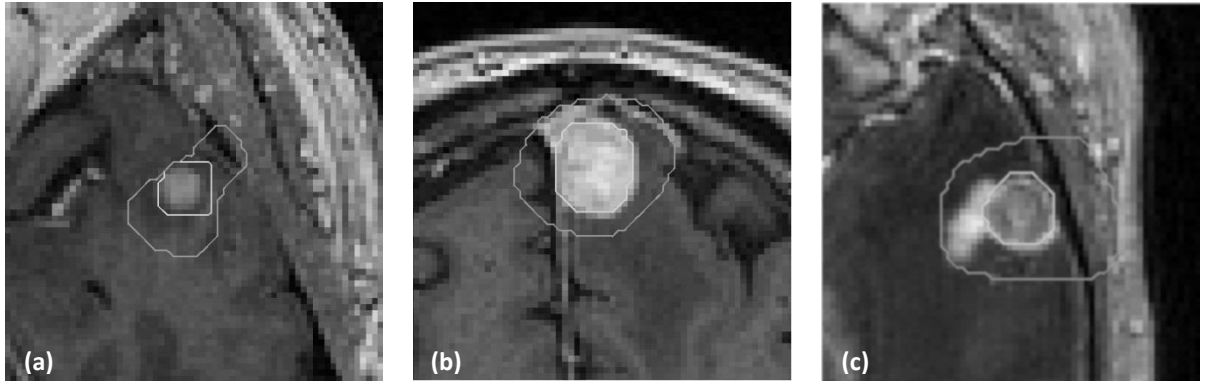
ROI bounding region generation on MR images: three examples of bounding region determined via DRLSE-based method, starting from IUR imported from the corresponding SUV_{max} PET slice.
